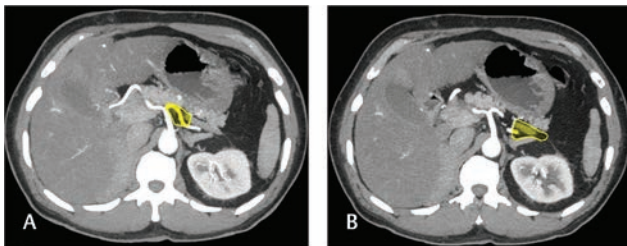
Station 11. Axial computed tomography (A) and (B) in arterial phase show station 11 location along proximal (A) and distal (B) splenic artery, that is, station 11p and 11d, respectively.
